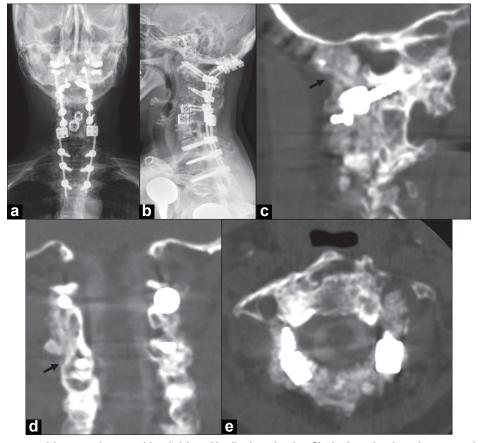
A 52-year-old woman with severe rheumatoid arthritis and basilar invagination. She had previously undergone multiple prior cervical procedures done at another hospital, including placement of anterior interbody cages at C4-C6. She subsequently required occipital-cervical instrumented arthrodesis and decompression using rhBMP-2 and cancellous allograft for treatment of basilar invagination. Postoperative AP and lateral radiographs are shown in panels a and b, respectively. CT imaging with sagittal (panel c) and coronal reconstructions (panel d) performed 19 months following surgery demonstrates brisk bony fusion extending from the occipital to C1 (panel c, arrow) and along the lateral masses (panel d, arrow). Axial CT imaging at the interspace of C1-C2 does not demonstrate canal encroachment (panel e).
